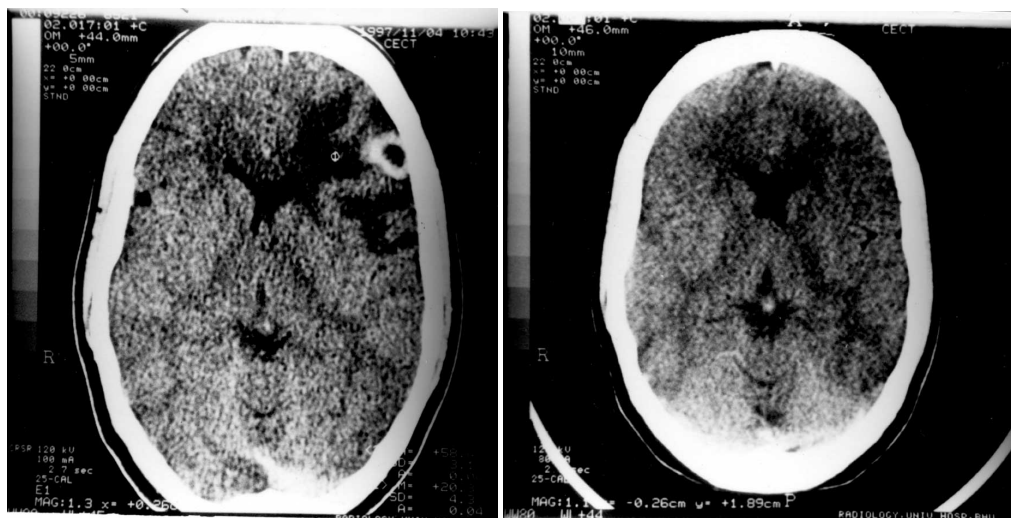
(a) A ring enhancing CT lesion with eccentric scolex; (b) follow-up scan after 2 months showing complete disappearance of the lesion and oedema.
